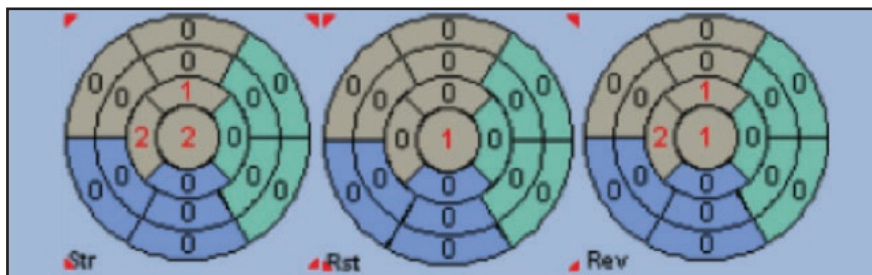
Seventeen segment polar map images from SPECT MPI showing an SSS of 5, SRS of 1, and SDS of 4, with quantitative ischemia in the distal/apical septal segment.
